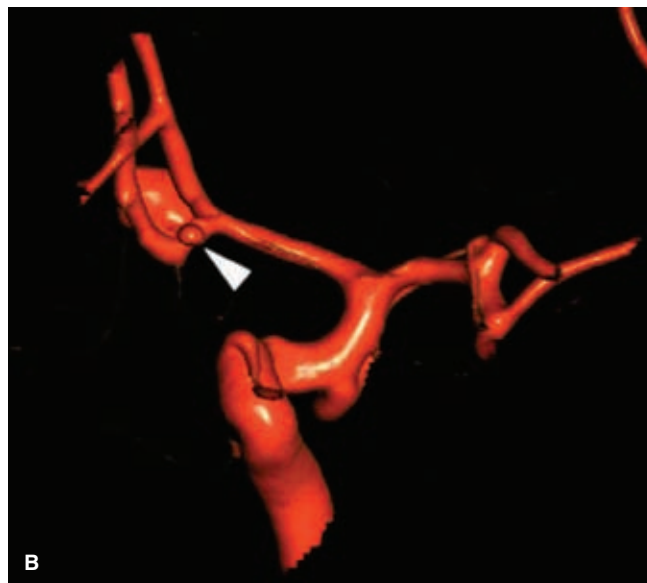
(A–F) Recurrence of aneurysm of the anterior communicating artery. A middle-aged patient presented with extensive subarachnoid hemorrhage (A), a Hunt and Hess grade 4 status, and was found to have a moderate-sized aneurysm of the anterior communicating artery on CTA. Rotational angiography (B) revealed a second tiny 2-mm adjacent aneurysm at the left A1–A2 junction (*arrowhead*) that could not be seen on conventional projections, until the aneurysm profile was established using the 3D data (C). (*continued*)
